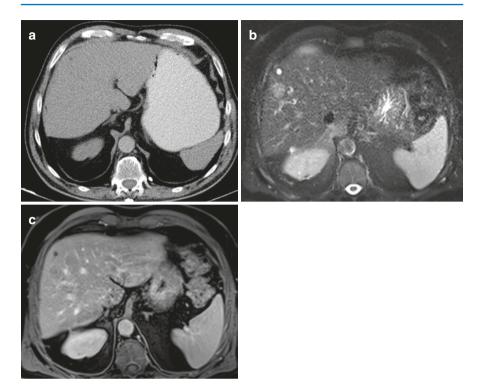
A 69-year-old male with biopsy-proven adenocarcinoma of the rectum. (a) Axial iv contrast-enhanced CT image demonstrates a non-specific millimetric hypodense lesion in the segment 8 of the right lobe of the liver. (b) Axial fat-saturated T2W MRI image demonstrates two adjacent hyperintense focal lesions in the segment 8 of the right lobe of the liver. The anteriorly located smaller lesion has a high T2 signal with distinct margins and the posteriorly located lesion is relatively faint. (c) Axial contrast-enhanced T1W image (portal venous phase) demonstrates no enhancement in the small lesion which is a simple cyst, whereas the other lesion shows slight peripheral enhancement and considered as metastasis
